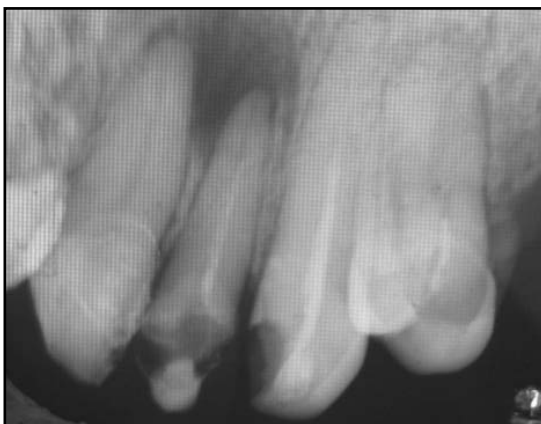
Incomplete root canal filling and periapical lesion in 22
